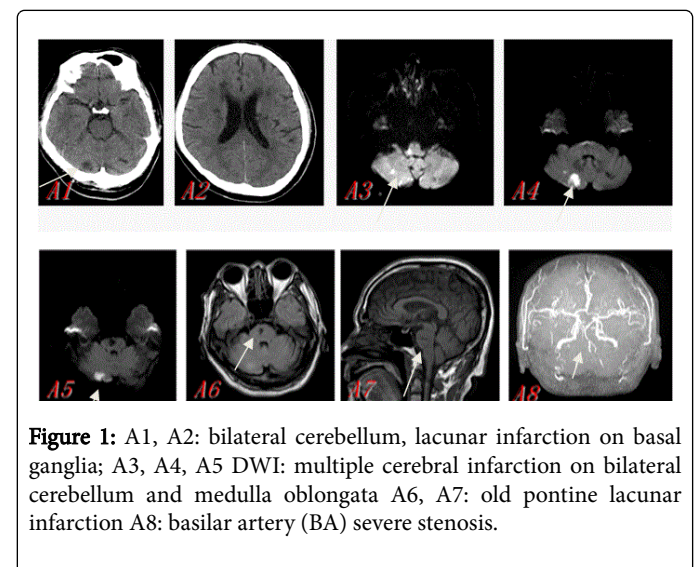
A1, A2: bilateral cerebellum, lacunar infarction on basal ganglia; A3, A4, A5 DWI: multiple cerebral infarction on bilateral cerebellum and medulla oblongata A6, A7: old pontine lacunar infarction A8: basilar artery (BA) severe stenosis.
